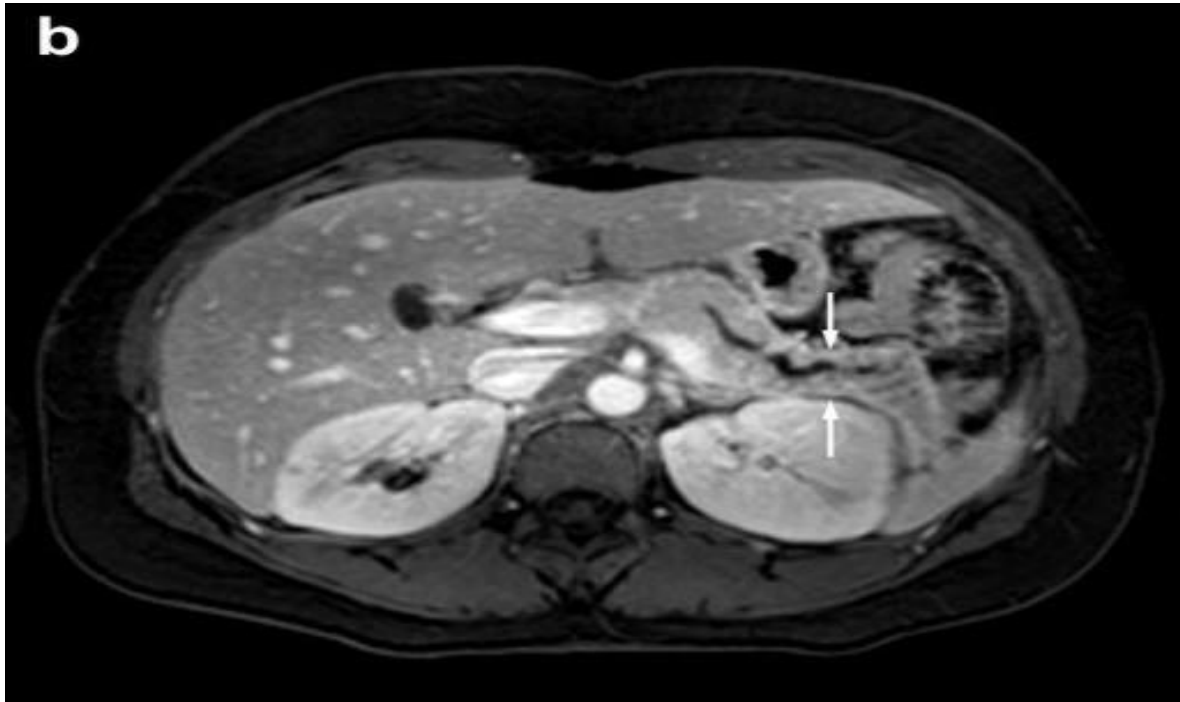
FIGURE SHOWING MRI IMAGE OF ACUTE PANCREATITIS
